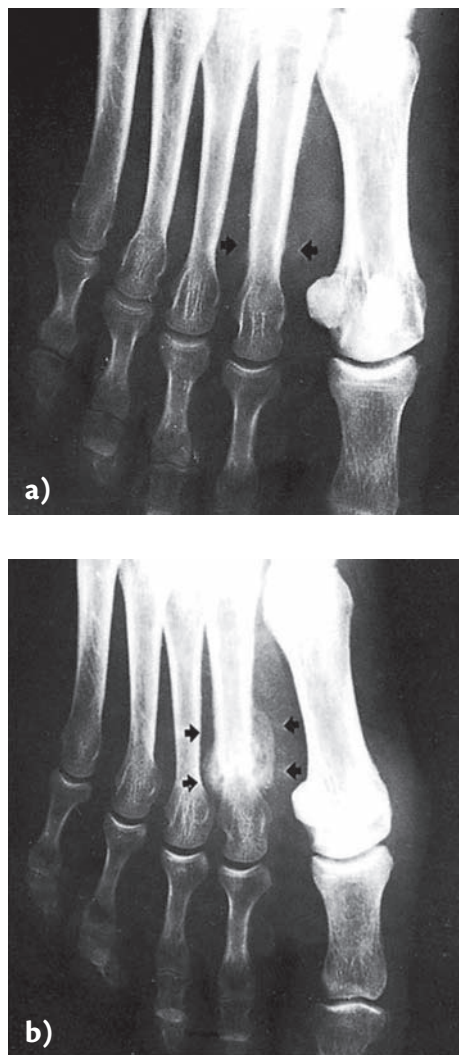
X-rays of a stress fracture. a) Image taken at the first examination showing signs of a stress fracture; b) image taken 1 month later; signs of healing with callus tissue around the stress fracture.
